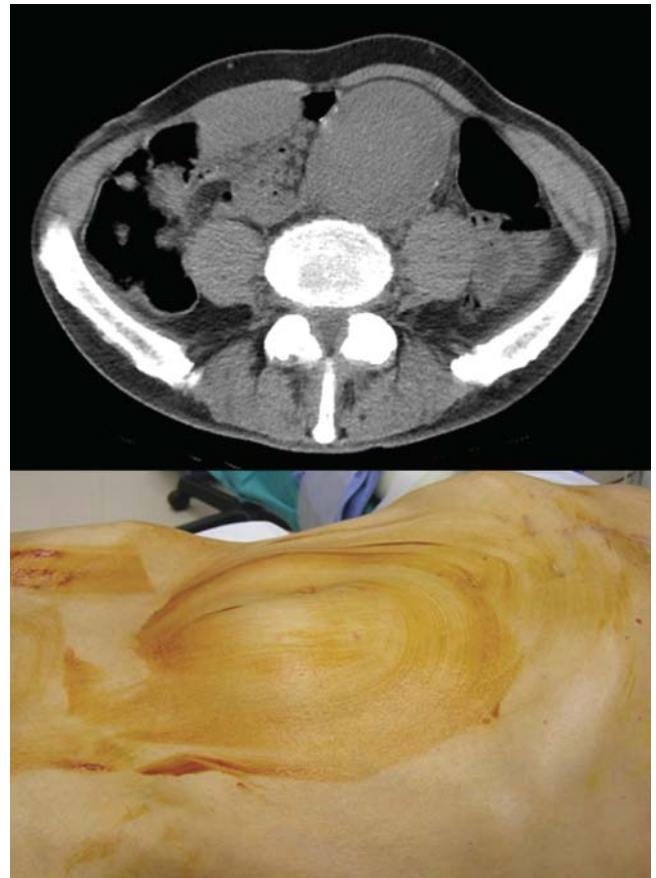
Visible, palpable abdominal mass. *Top:* Axial computed tomographic scan of the abdomen demonstrating how an abdominal aortic aneurysm can deform the abdominal wall in a thin patient. *Bottom:* Photograph of the same patient demonstrating the visible deformity of the anterior abdominal wall.
